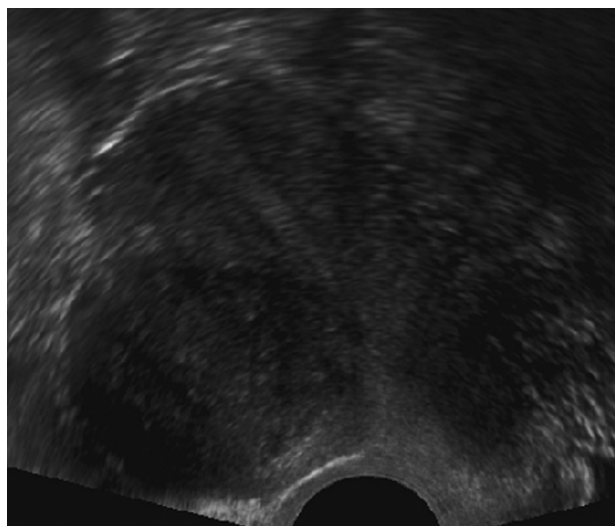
Preoperative ultrasonography image of proband 1.
